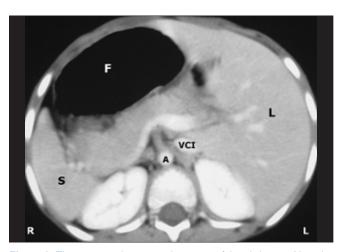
The computed tomography image of the abdomen. Note the situs inversus anatomy of the abdominal organs. A: Aorta F: Fundus of the stomach L: Liver S: Spleen VCI: Vena Cava Inferior
